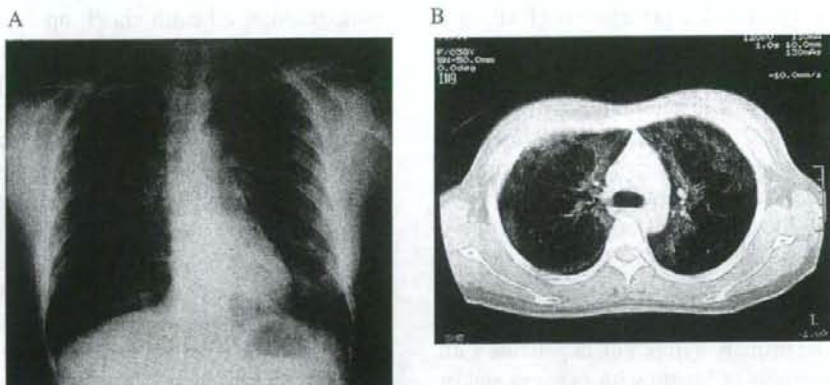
Radiographic appearance on admission (August 5, 2002). Diffuse infiltrative shadows are seen in both lung fields on chest radiogram (A). Chest computerized tomography (CT) shows opacification with a patchy distribution. The distribution was widespread but more prominent at the peripheral portion (B).
